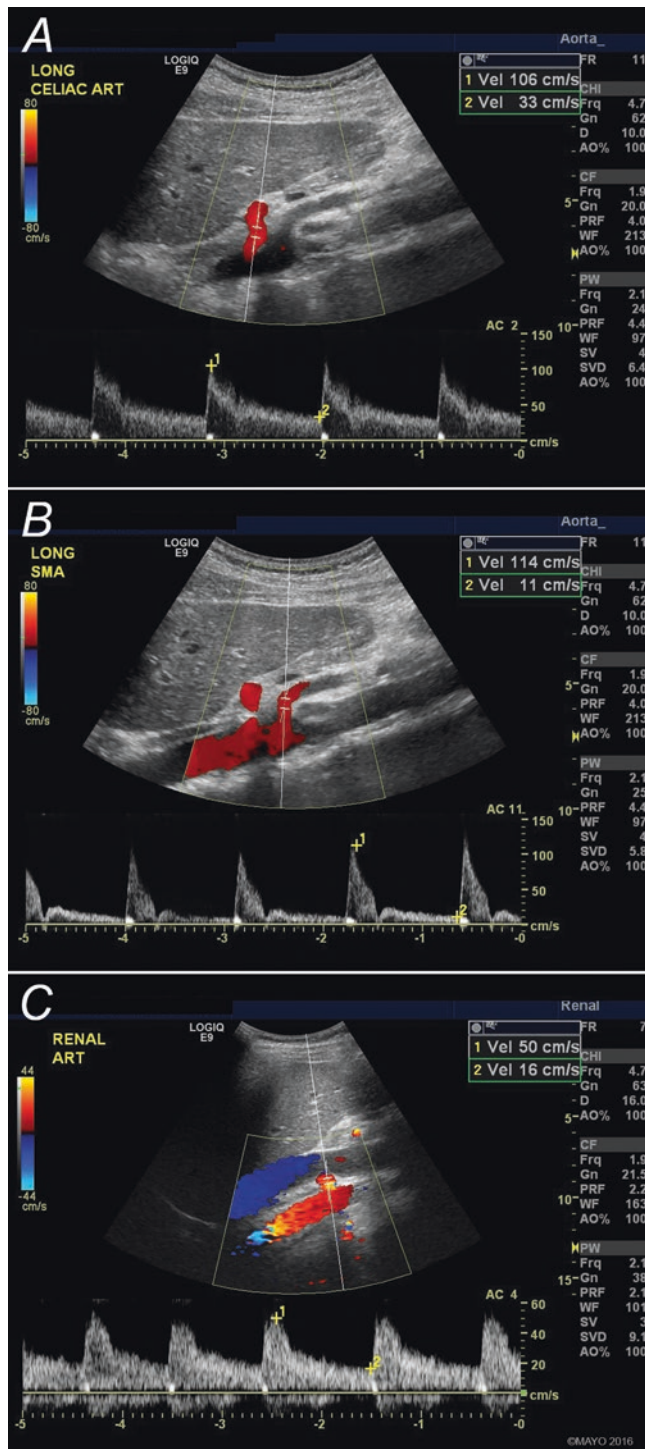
Normal mesenteric and renal spectral Doppler waveform. The celiac artery has a low resistance waveform reflecting the constant high blood supply to the liver and spleen with persistent flow throughout diastole (a). The superior mesenteric artery has a high resistance waveform in fasting state with diminished flow through diastole (b) and a low resistance waveform during post-prandial state reflecting the increased blood flow necessary for food absorption. Similarly to the liver, the kidneys require constant high blood flow, consequently the normal renal artery waveform will have a low resistance pattern (c). By permission of Mayo Foundation for Medical Education and Research. All rights reserved
